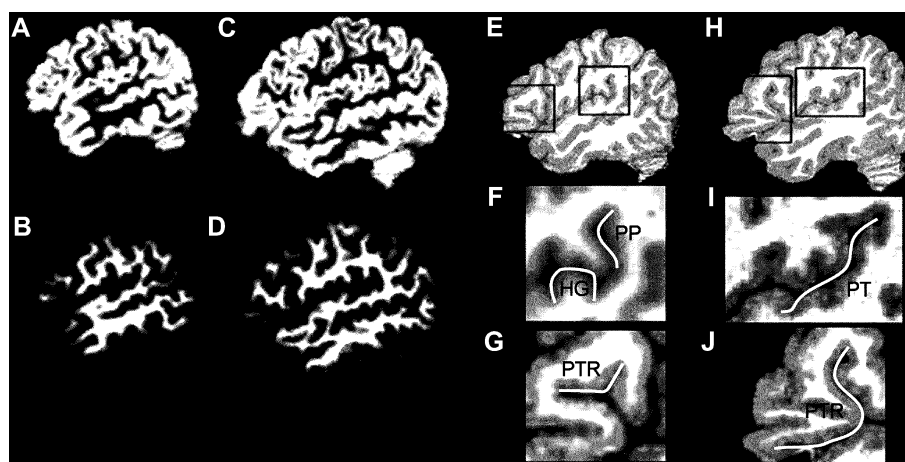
Sagittal images. (A) Partial volume estimate (PVE) image of gray matter in individual with low cerebral volume. The percentage of gray matter in each pixel is estimated on a scale ranging from 0 (black) to 1 (white). (B) PVE image of white matter in individual A. (C) PVE image of gray matter in individual with high cerebral volume. (D) PVE image of white matter in individual C. (E) T1 weighted image of left hemisphere with small pars triangularis (PTR), Heschl's gyrus (HG), planum temporale (PT), and relatively large planum parietale (PP). Boxes depict regions magnified in (F and G). (H) T1-weighted image of left hemisphere with large PTR, HG, PT, and absent PP. Boxes depict regions magnified in (I and J). White lines in (F), (G), (I), and (J) are tracings of surface areas.
